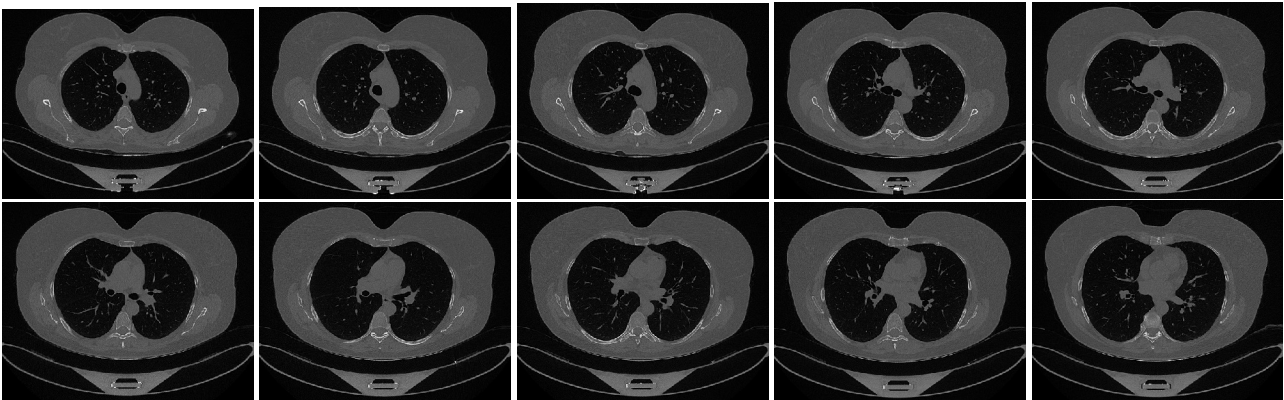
Slices from non COVID-19 case in COV19-CT-DB
